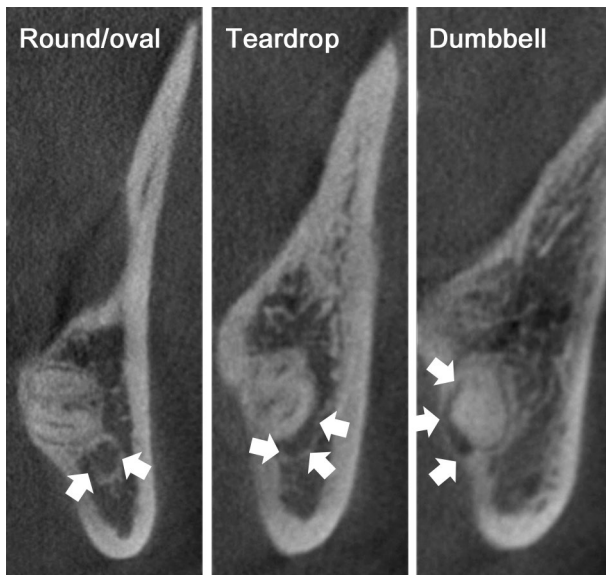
Shape of the inferior alveolar canal (IAC) on cone-beam computed tomography. The IAC shape (arrows) was categorized as round/oval, teardrop, and dumbbell on the coronal section in the closest proximity between the lower third molars and IAC [9]
